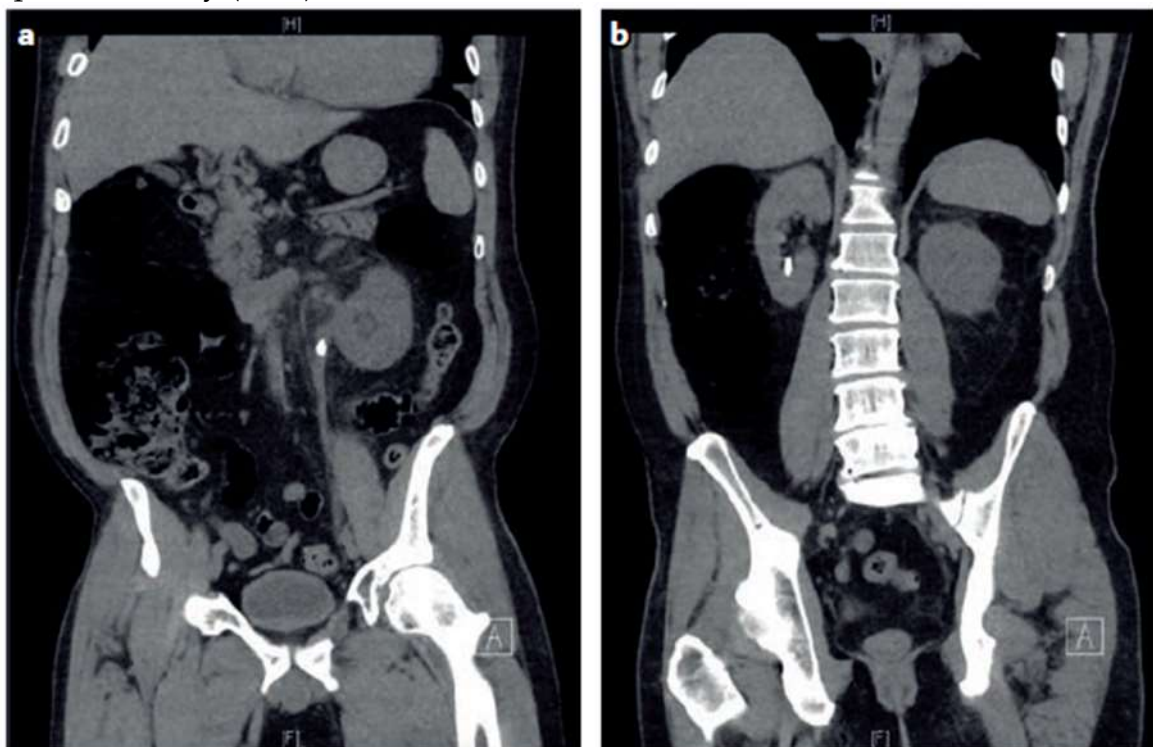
Coronal view of bilateral nephrolithiasis measuring 8 mm on non-contrast CT. The stone is clearly visible using this imaging modality. Additional anatomic detail can be obtained by reconstructing the image in the axial plane. a. This coronal CT image clearly shows an obstructive stone on the left side. b. The posterior coronal CT view from panel a shows a non-obstructive stone at the lower pole of the kidney. An excellent level of anatomic detail is seen in these images and can be further enhanced by image reconstruction in the axial plane.
